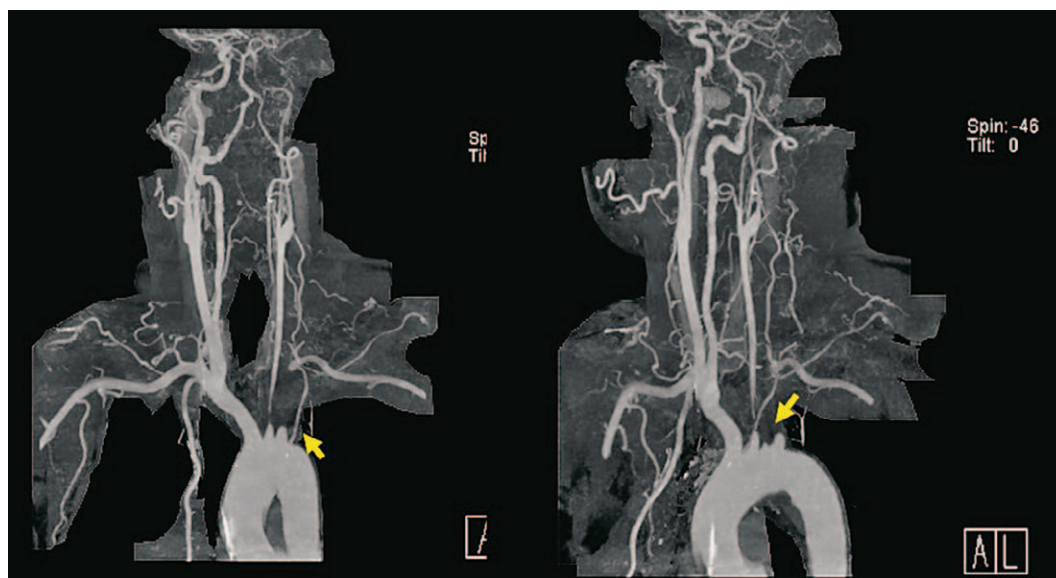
Neck and brain CT angiogram. Stenosis involving the origin of the left common carotid artery and left subclavian artery, with extensive collaterals of the vertebral arteries and basilar artery
